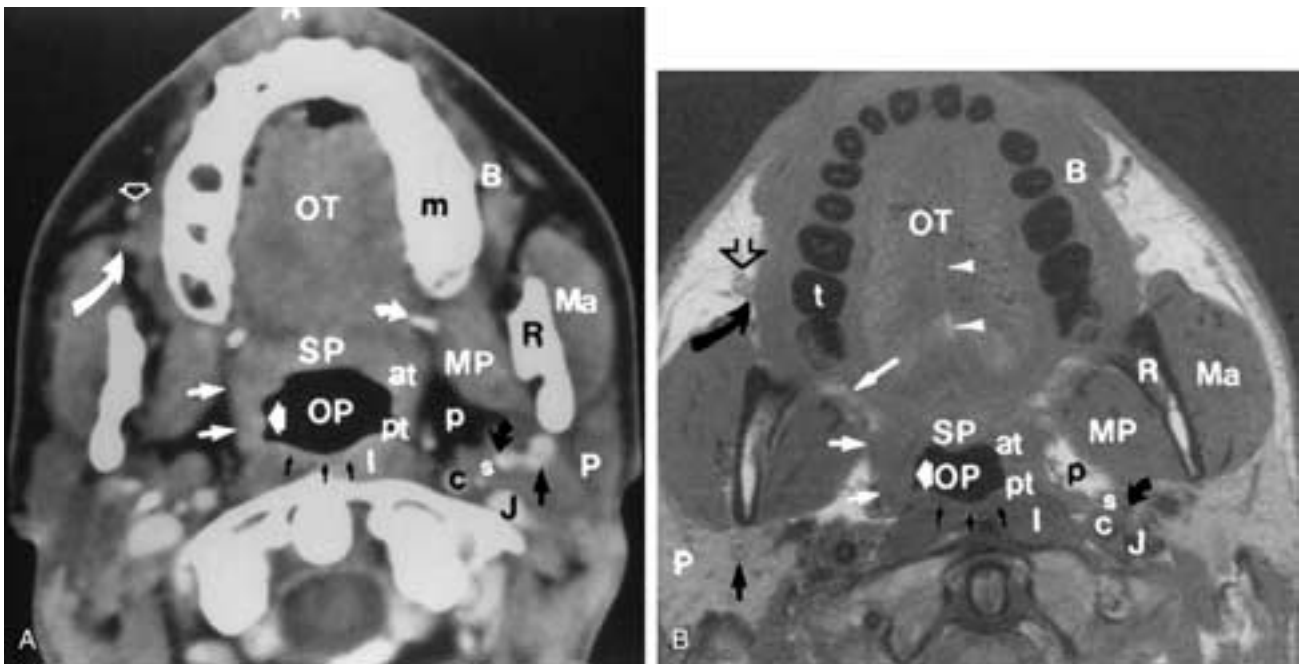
Normal anatomy of the oropharynx and surrounding structures. A, CT: B, Buccinator muscle; OT, oral tongue; m, maxillary alveolar ridge; white curved arrow, hook of the hamulus; SP, soft palate; Ma, masseter muscle; R, ramus of the mandible; MP, medial pterygoid muscle; open arrow, angular vein; large curved arrow, parotid duct; OP, airway of the oropharynx; at, region of the anterior tonsillar pillar (palatoglossus muscle); pt, region of the posterior tonsillar pillar (palatopharyngeus muscle); fat white arrow, tonsillar fossa (palatine, faucial tonsil); small black arrows, posterior wall of the oropharynx; l, longus colli muscle; p, fat within the prestyloid parapharyngeal space; curved black arrow, styloid process; s, origin of the styloid musculature; P, parotid gland; straight black arrow, retromandibular vein; c, internal carotid artery; J, internal jugular vein. B, MR: B, Buccinator muscle; OT, oral tongue; t, tooth arising from the maxillary alveolar ridge; large straight white arrow, location of the pterygomandibular raphe, which is attached above to the hook of the hamulus; SP, soft palate; Ma, masseter muscle; R, ramus of the mandible; MP, medial pterygoid muscle; open arrow, angular vein; large curved arrow, parotid duct; OP, airway of the oropharynx; at, region of the anterior tonsillar pillar (palatoglossus muscle); pt, region of the posterior tonsillar pillar (palatopharyngeus muscle); fat white arrow, tonsillar fossa (palatine, faucial tonsil); small black arrows, posterior wall of the oropharynx; l, longus colli muscle; p, fat within the prestyloid parapharyngeal space; curved black arrow, styloid process; s, origin of the styloid musculature; P, parotid gland, retromandibular vein; c, internal carotid artery; J, internal jugular vein. (Reprinted with permission from Mukherji SK, Castillo M. Normal cross-sectional anatomy of the nasopharynx, oropharynx, and oral cavity. *Neuroimaging Clin North Am* 1998;8:211–218, Fig. 3.)
